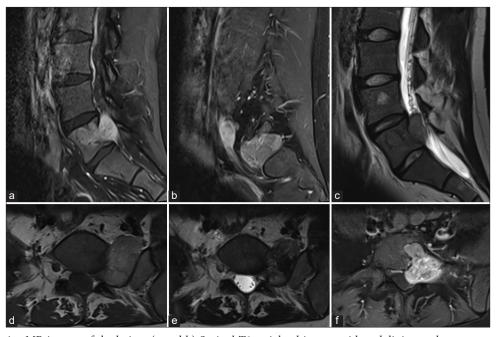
Preoperative MR images of the lesion. (a and b) Sagittal T1-weighted images with gadolinium enhancement of the lumbosacral spine demonstrating diffuse, heterogenous enhancement of the lesion with involvement the posterior aspect of the L5 vertebrae extending laterally to the retroperitoneal space. (c) Sagittal T2-weighted MR image showing extension of the lesion into the spinal canal and incidental hemangioma in the L4 vertebral body. (d) Axial T1-weighted MR image with lesion exiting the left L5/S1 foramen. (e) Axial T2-weighted MR image with lesion demonstrating low signal. (f) Axial T1-weighted image of the lesion with gadolinium enhancement showing heterogenous enhancement and rightward displacement of the thecal sac.
